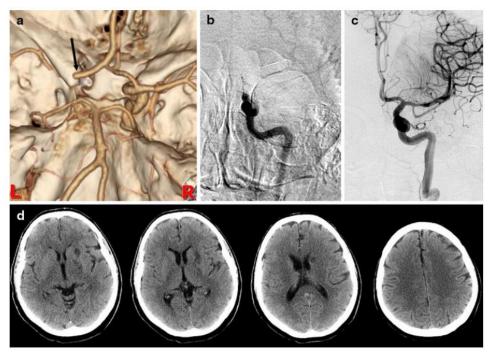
(Patient 5) a Angio-computed tomography (CT) represented by volume rendering (*left*) and Multi Planar Reconstruction technique (right). Occlusion of the left distal internal carotid artery (ICA). The efficient AcomA allows the filling of the left A1 (*arrow with dot*). Both PCAs (*arrows*) arise from the basilar artery. b Left carotid angiogram
